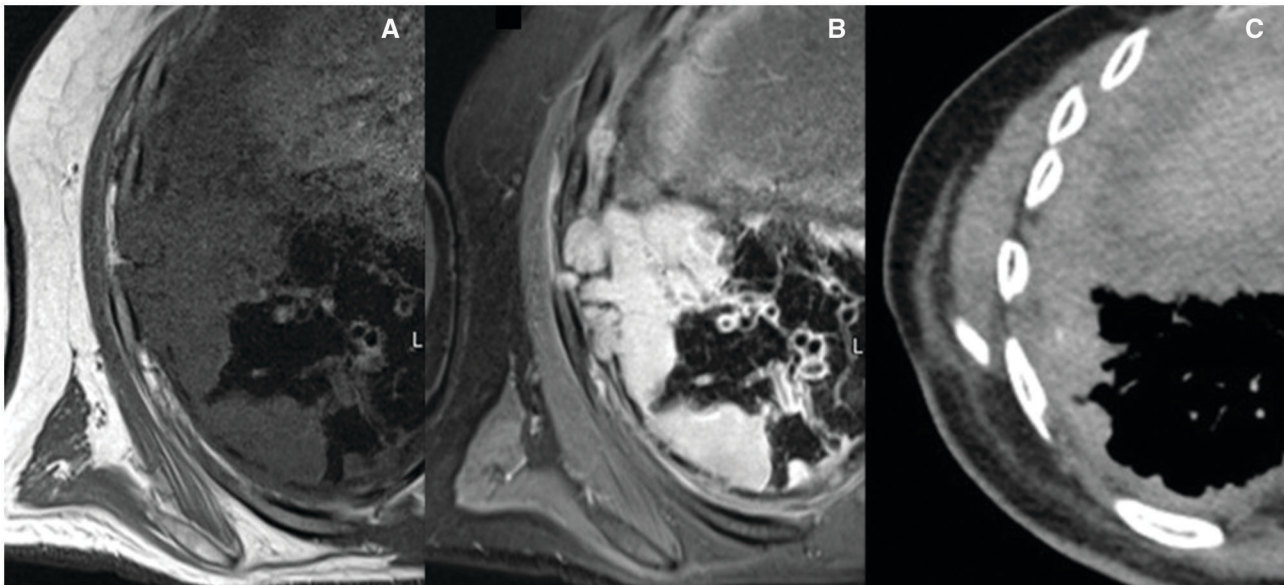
A-C. T1W axial (A), T1 fat saturated axial post-gadolinium (B) and contrast enhanced axial CT (C) images in a patient with a right sided mesothelioma. The chest wall invasion is better appreciated on the MR images and only seen as subtle loss of fat planes on contrast-enhanced CT.
